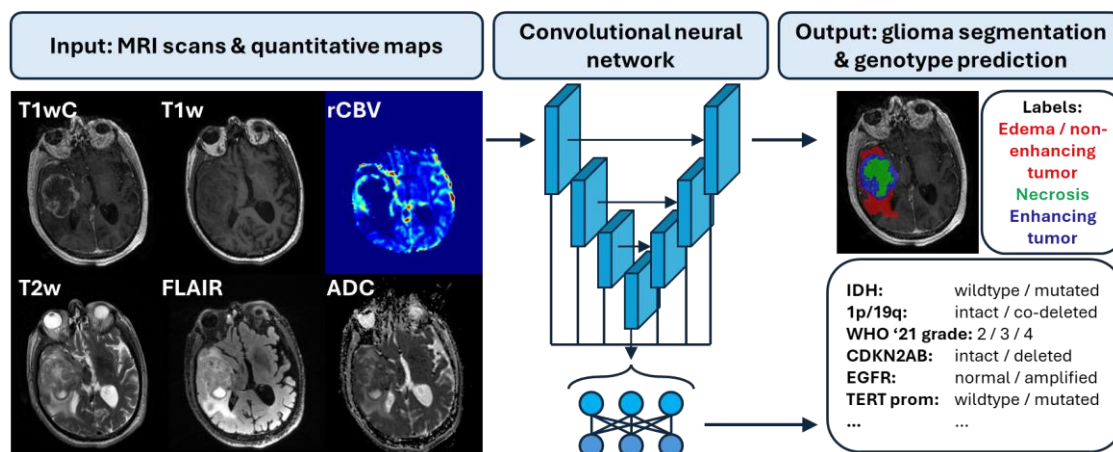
Overview of the method. A multitask U-Net will be trained to segment gliomas into three subregions and predict genotype and grade from structural MRI quantitative maps.
